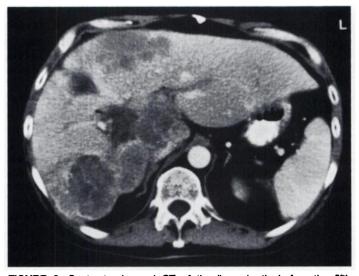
Contrast-enhanced CT of the liver shortly before the fifth [1³¹][MIBG therapy demonstrates multiple solid tumors of the liver beside normal liver tissue.
